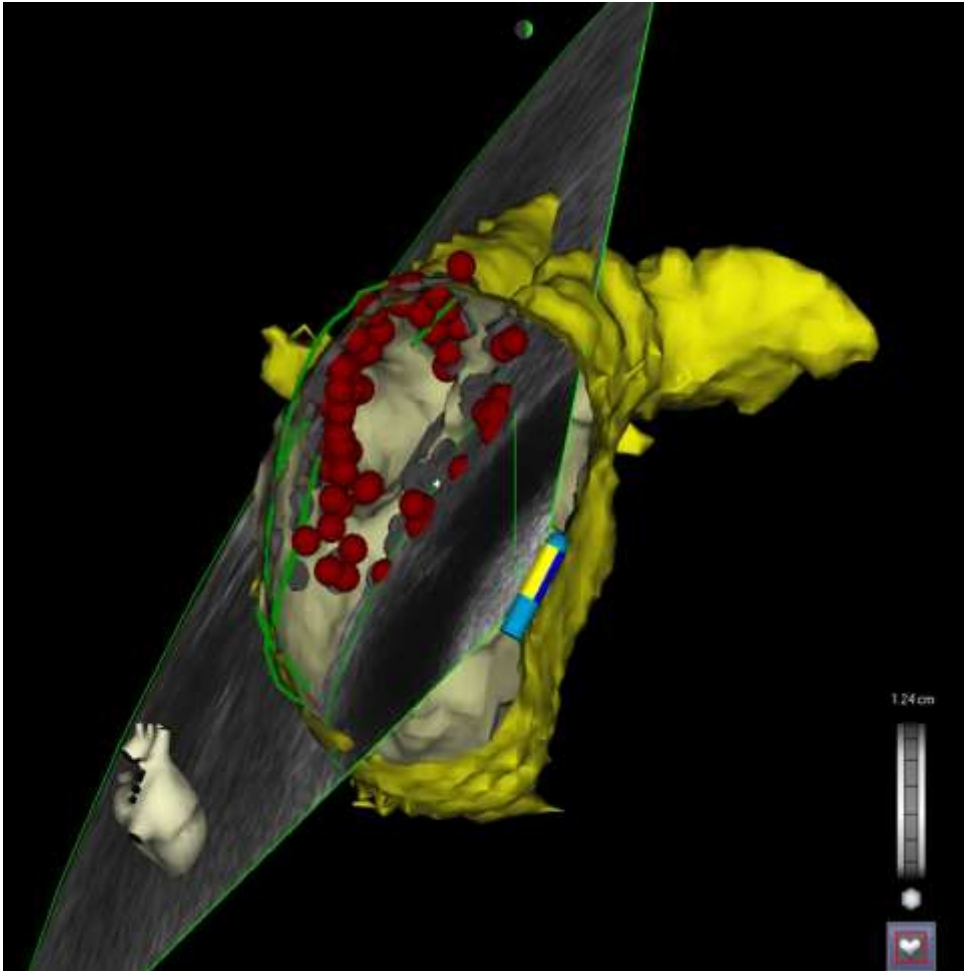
After registration the three-dimensional map created with intracardiac echocardiography and integrated multi-slice computed tomography image were used to facilitate the ablation procedure. Circumferential lesions were created outside the pulmonary vein ostia. Red tags represent the sites of radiofrequency current application.
